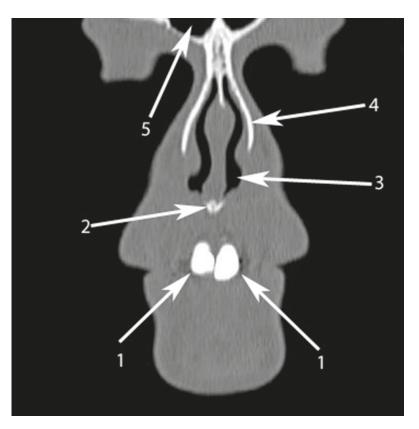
Coronal CT scan at the level of central incisors. *Numbers* with *arrows* denote the following anatomical structures: 1 – central incisors; 2 – anterior nasal spine; 3 – nasal cavity; 4 – frontal process of the maxillary bone; 5 – frontal sinus.
